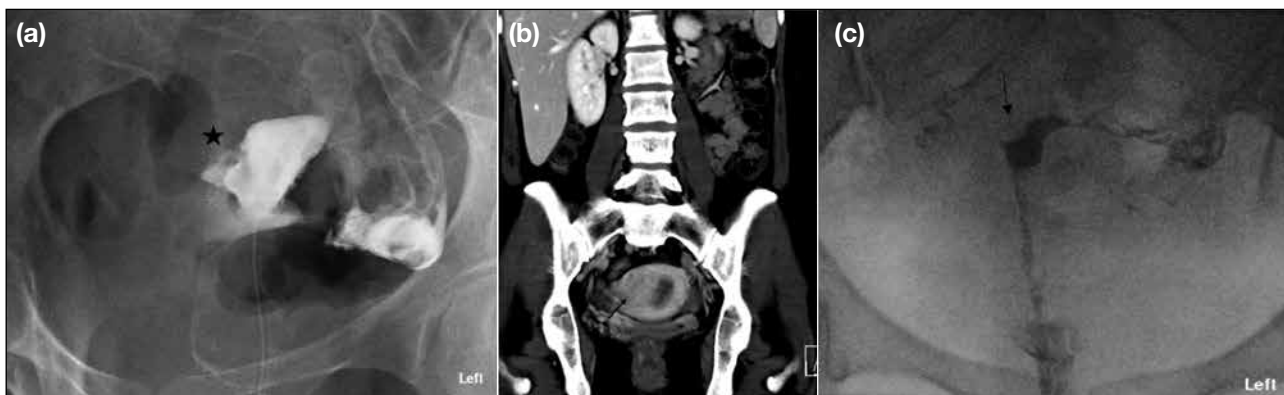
(a and b) A 29-year-old woman with leiomyoma indenting the uterine cavity. (a) Hysterosalpingography showed indentation (star) of the right uterine cavity. (b) Follow-up computed tomography scan of the abdomen and pelvis showed a hypo-enhancing uterine mass (arrow) suggestive of leiomyoma with displacement and indentation of the right fundal uterine cavity. (c) A 36-year-old woman with submucosal leiomyoma. Hysterosalpingography showed a filling defect at right cornual region (arrow) with smooth border. Hysteroscopy showed a fundal polypoid lesion and polypectomy was performed. Pathology revealed submucosal leiomyoma.
